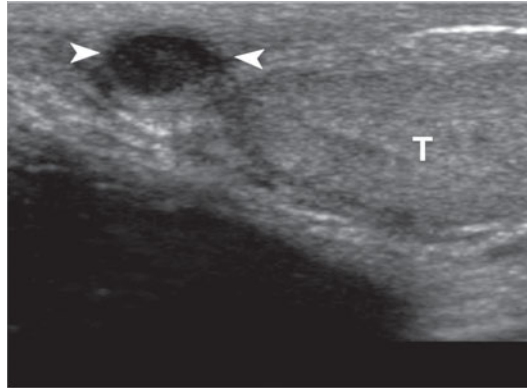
Torsion of the appendix testis in pediatric patient. The testicle (T) shows normal volume and echotexture. Intraparenchymal flow on color Doppler is normal. In proximity to the head of the epididymis a hypoechoic nodule can be identified (arrowheads)
